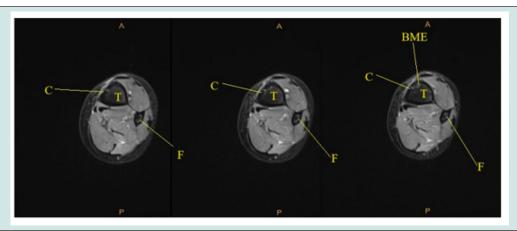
Three axial slices of Magnetic Resonance Imaging (MRI) of left tibia/fibula. Cortical defect identified (C), with improving bone marrow edema (BME), suggestive of healing stress fracture of the anterior and medial distal tibial metadiaphysis. Tibia (T) and Fibula (F).
